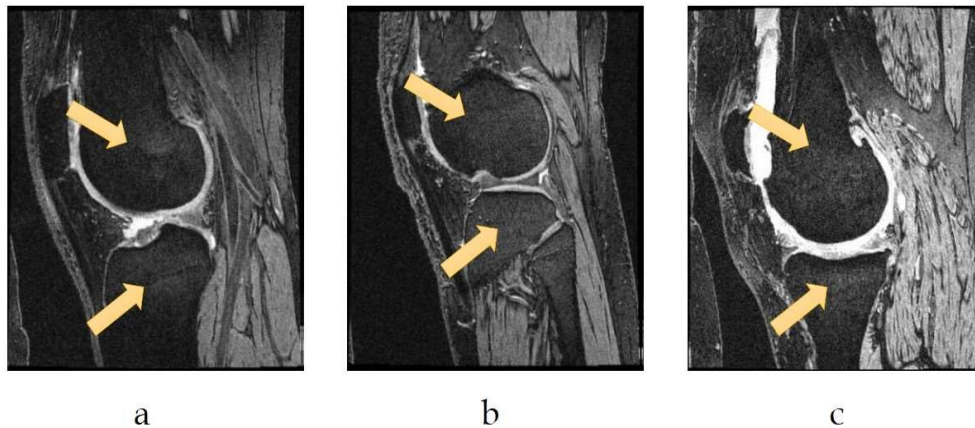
Different views of knee MR image (Sagittal view)
